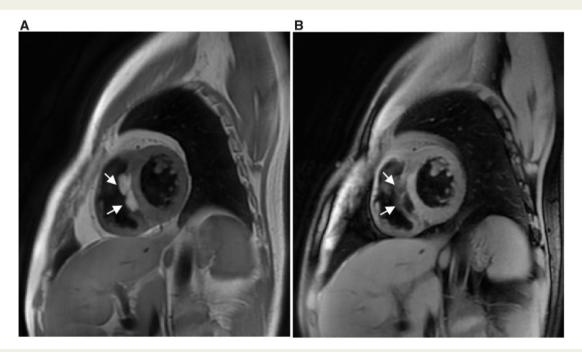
The masses revealed a hyperintense signal in the T1-weighted image and was uniformly suppressed in the fat-suppression mode (A and B, white arrows).
